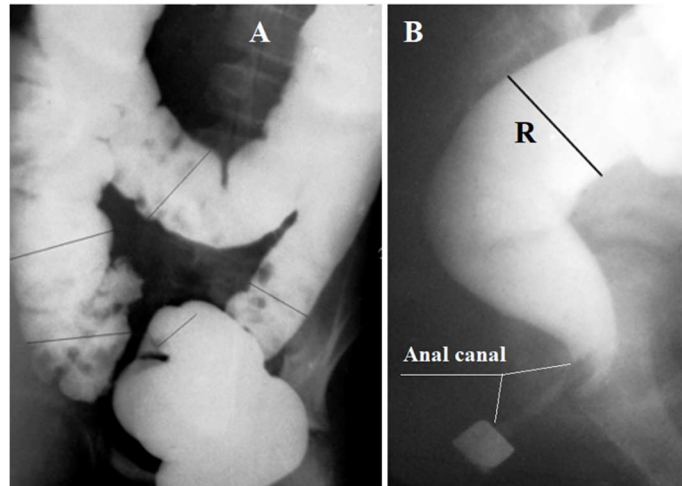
A. On the frontal radiograph, lines mark the measurement sites of all parts of the colon. In the conglomerate of loops of the sigmoid colon and rectum, the rectum is not differentiated and cannot be measured. B). Only on the lateral radiograph of the anorectum can one measure the width of the vertical part of the rectum and the length of the anal canal from the rectum to the marker near the anal dimple. Knowing the true diameter of the contrast marker, one can calculate the true width of the rectum (R) and the length of the anal canal.
